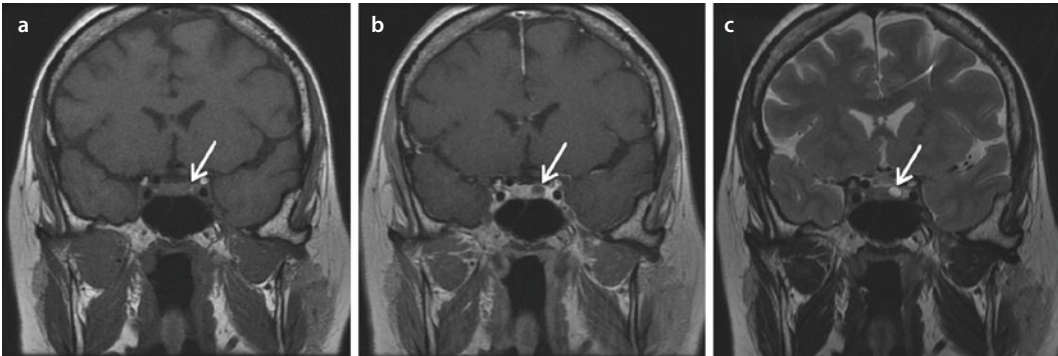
Pituitary MRI. a Coronal T1 non-contrast image—a mass (arrow) isointense with the normal anterior pituitary; b coronal T1 contrast-enhanced image—a mass (arrow) in the left side of the sella, hypointense compared to intensely enhancing anterior pituitary; c coronal T2 image—a mass (arrow) in the left is hyperintense compared to the anterior pituitary (Department of Diagnostic Imaging University Hospital in Krakow, Poland)
